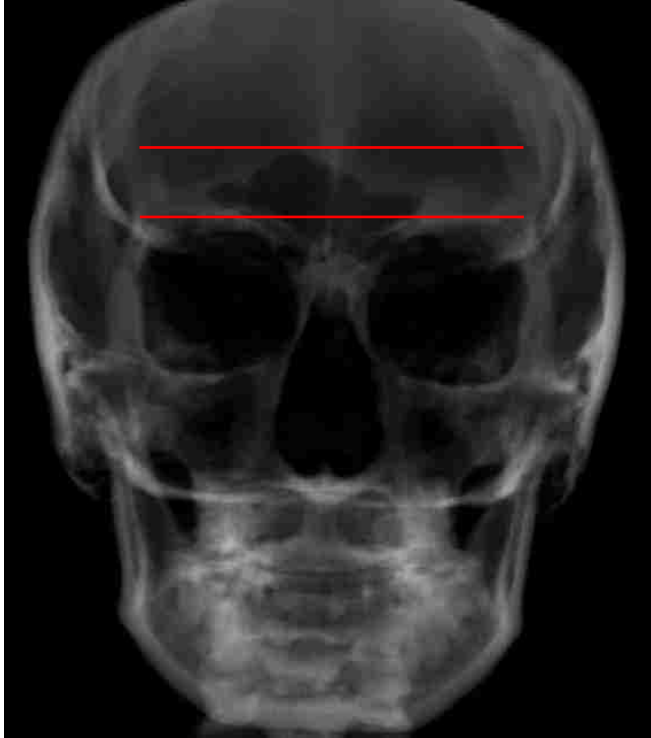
Superior and inferior borders of the frontal sinus from a frontal view (PA radiograph derived from CBCT using Invivo 5.3 Software)
